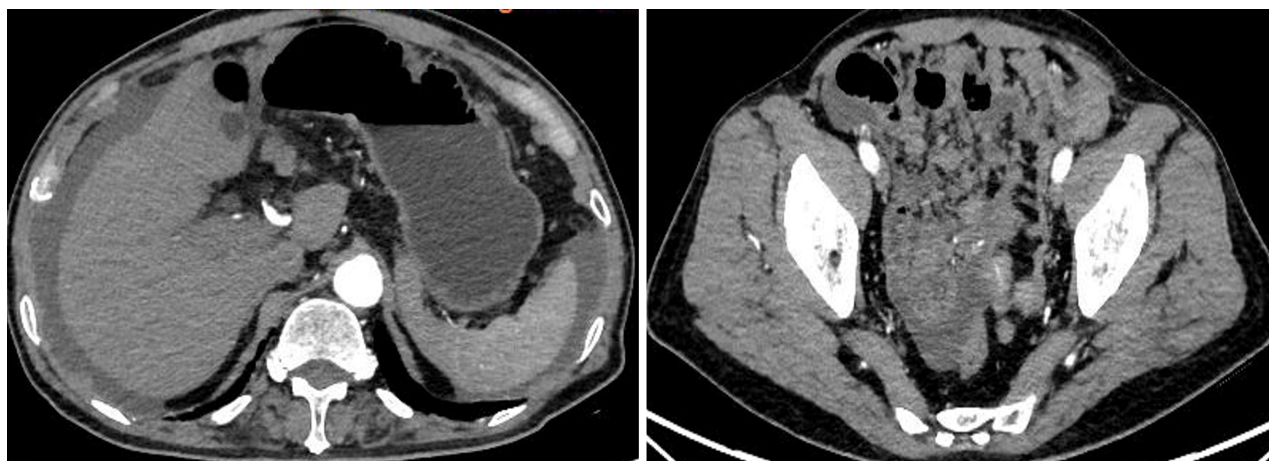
Preoperative abdominal computed tomography. Surgical exploration shows that the masses in abdominal cavity had spontaneous necrosis and bleeding.
